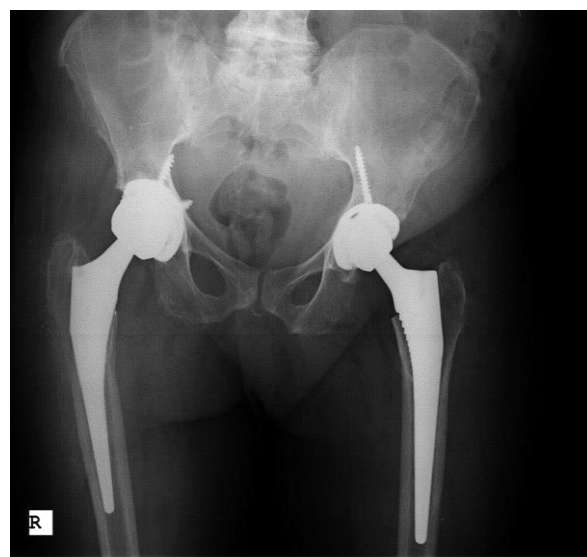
Follow-up pelvic X-ray [Anteroposterior (AP) view]
